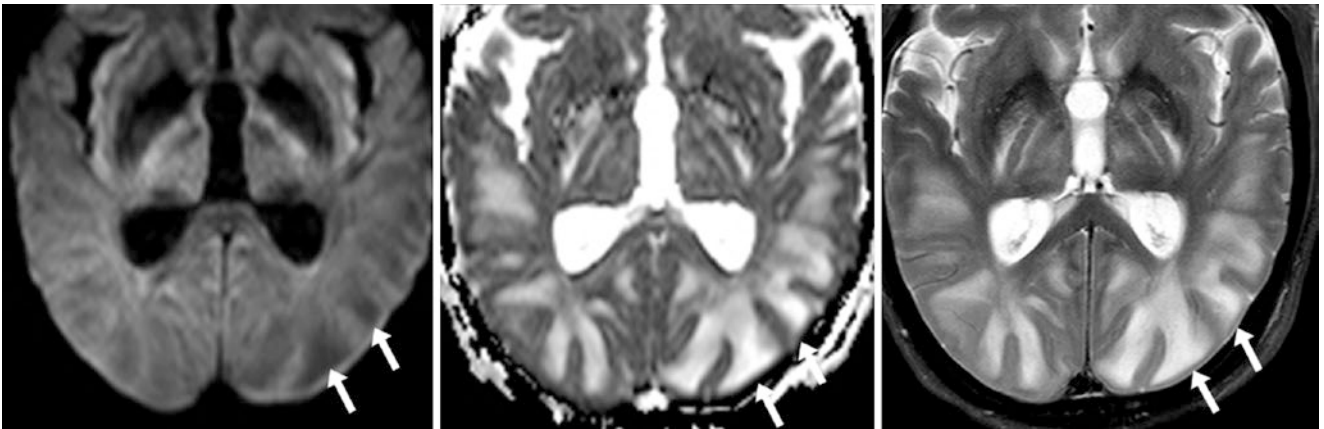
A 3 T MRI in a 60-year-old with PRES from rituximab therapy. The bright vasogenic edema (*arrows*) from PRES caused T2 washout unilaterally within the left temporal and occipital lobes on
